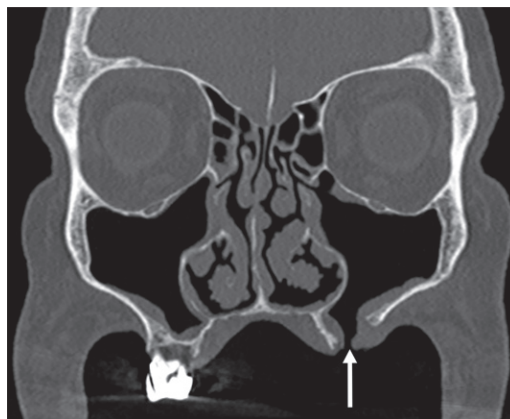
Oroantral fistula. Coronal nonenhanced CT image (bone window) demonstrates a bony defect connecting the left maxillary sinus floor with the oral cavity. The puffed cheek technique made diagnosis possible by separating the adjacent soft tissues and filling the fistulous tract with air (arrow).
